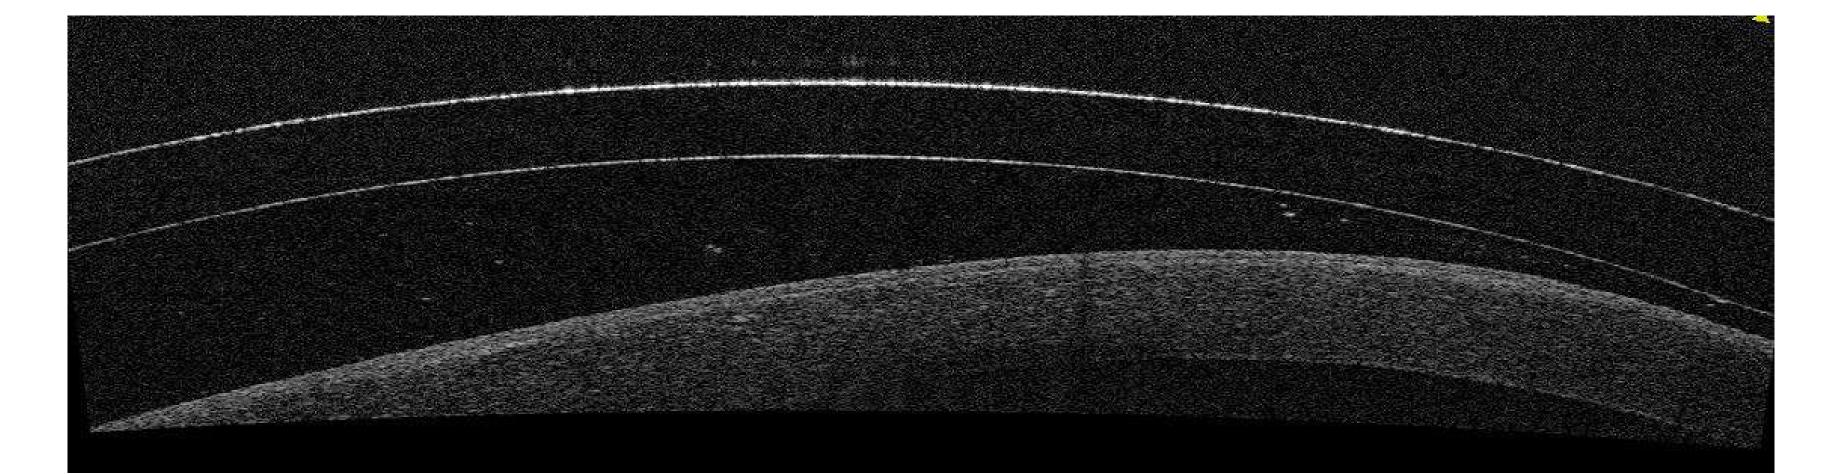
A representation of the best possible scleral lens fit achievable. Excessive superior clearance is noted to the left of the image, with minimal clearance inferiorly. (Lens CT: 350 microns)
